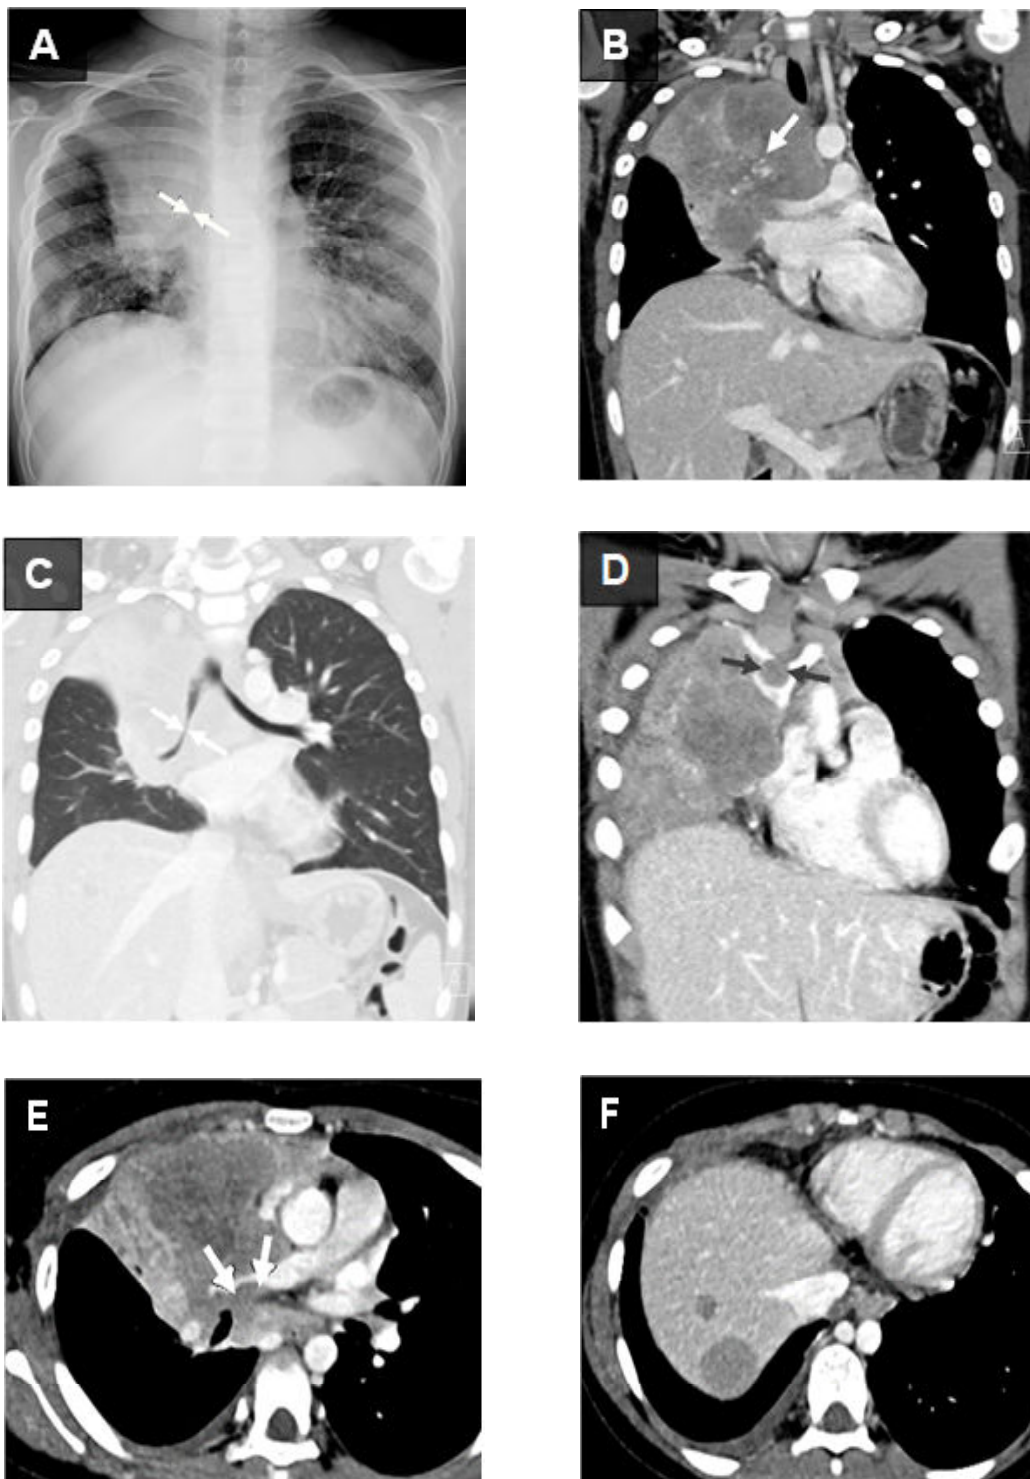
A 10-year-old boy with shortness of breath and hemoptysis. (A) Chest radiography showed mass-like opacity in the upper and middle right hemithorax with narrowing of the right bronchus intermedius (arrow) and evidence of loss of volume in the right lung. Subsequent chest CT revealed a heterogeneous enhancing large lobulated mass with internal calcification (arrow) involving the anterior to middle mediastinum, as well as right upper and middle lobes; (B) This mass obliterated the right upper and middle lobar bronchi; (C) and invaded directly the SVC (arrows in D) and the right pulmonary artery (arrows in E). Presence of subcarinal nodal metastases (E) and liver metastases (F).
